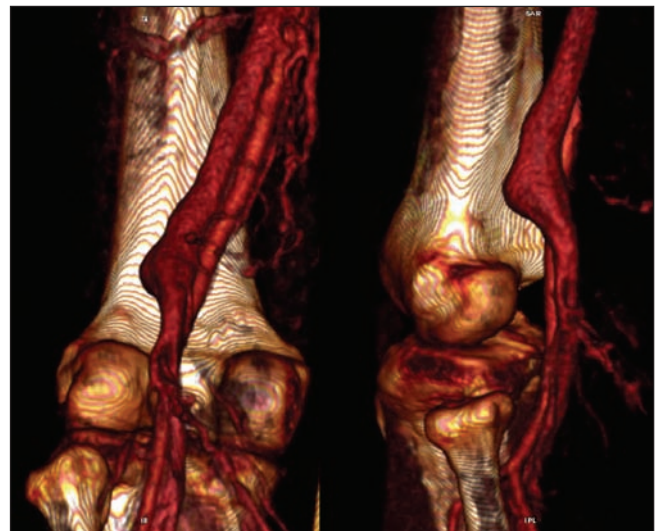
CT venogram demonstrating the left popliteal vein aneurysm.
